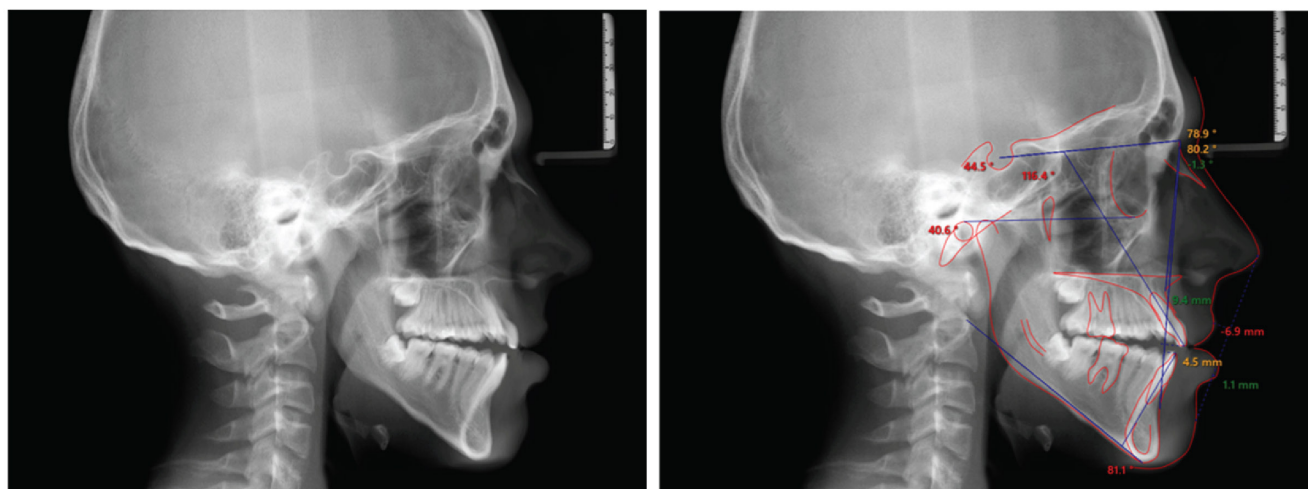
Pre-treatment lateral view of cephalometric radiograph. Pre-treatment lateral cephalometric radiograph shows a skeletal Class III relation, hyperdivergent profile, proclined maxillary incisors, and a skeletal open bite.
